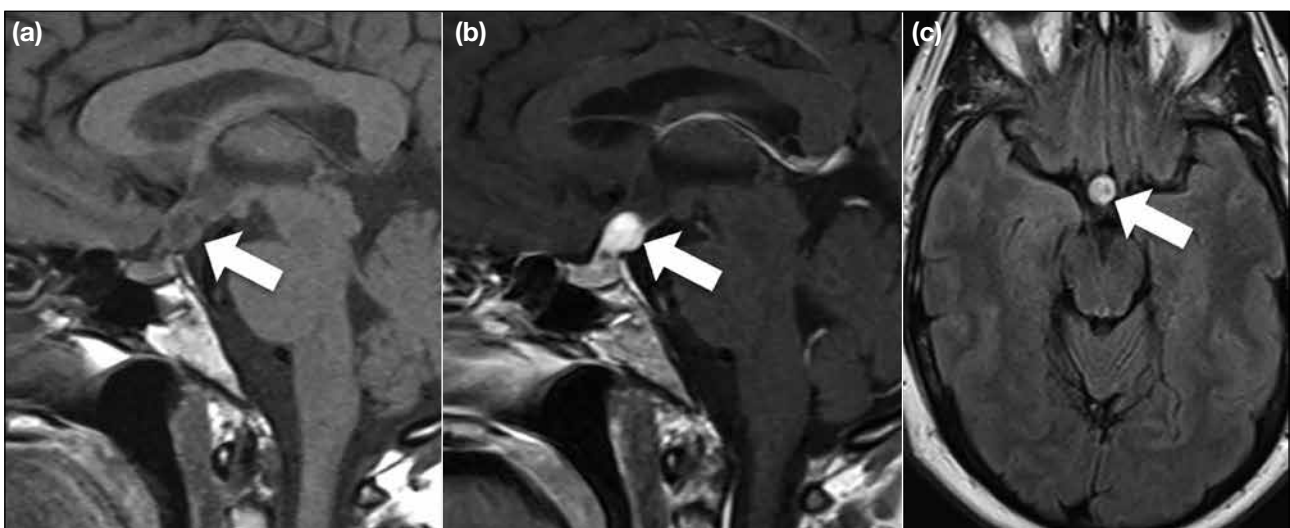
Pituitaryoma. This case shows a well-defined iso- to hypointense suprasellar lesion (arrow) on sagittal T1-weighted image before contrast injection (a) and the lesion (arrow) is strongly enhanced after contrast injection (b). The lesion is iso- to hyperintense (arrow) on axial T2-weighted fluid-attenuated inversion recovery image (c).
